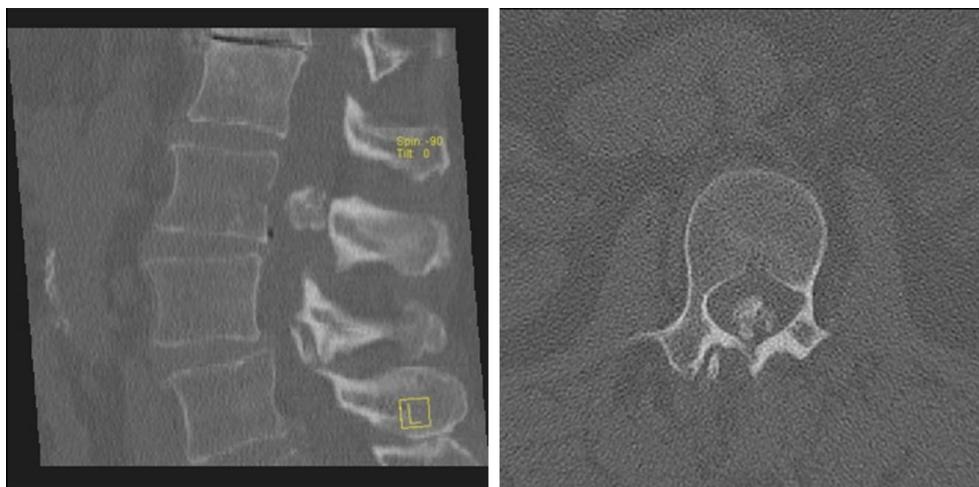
Computed tomography (CT) of the level L1–L4 showing (sagittal section on the *left*, axial section on the *right side*) a round, partially calcified mass with an approximate size of 1.4 cm × 1.5 cm × 1.3 cm without any contact to the facet joints or any other bony compartment
